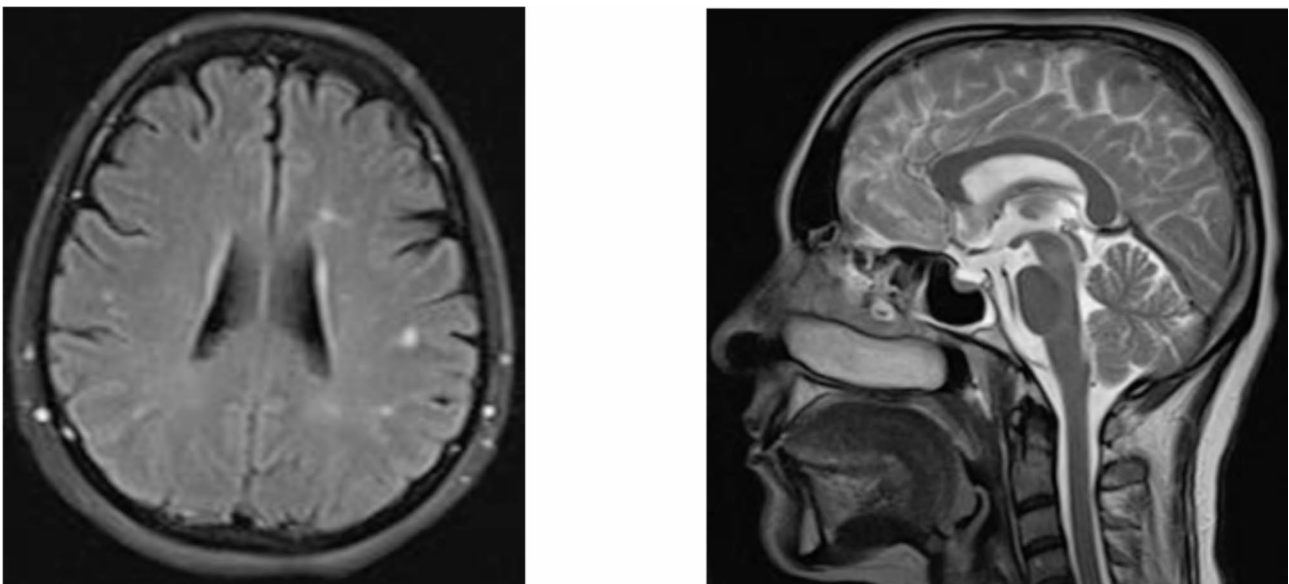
Brain MRI of case 3: (left) axial image of multiple abnormal signal intensity in subcortical and juxtacortical white matter; (right) sagittal T2 image with partial empty sella
